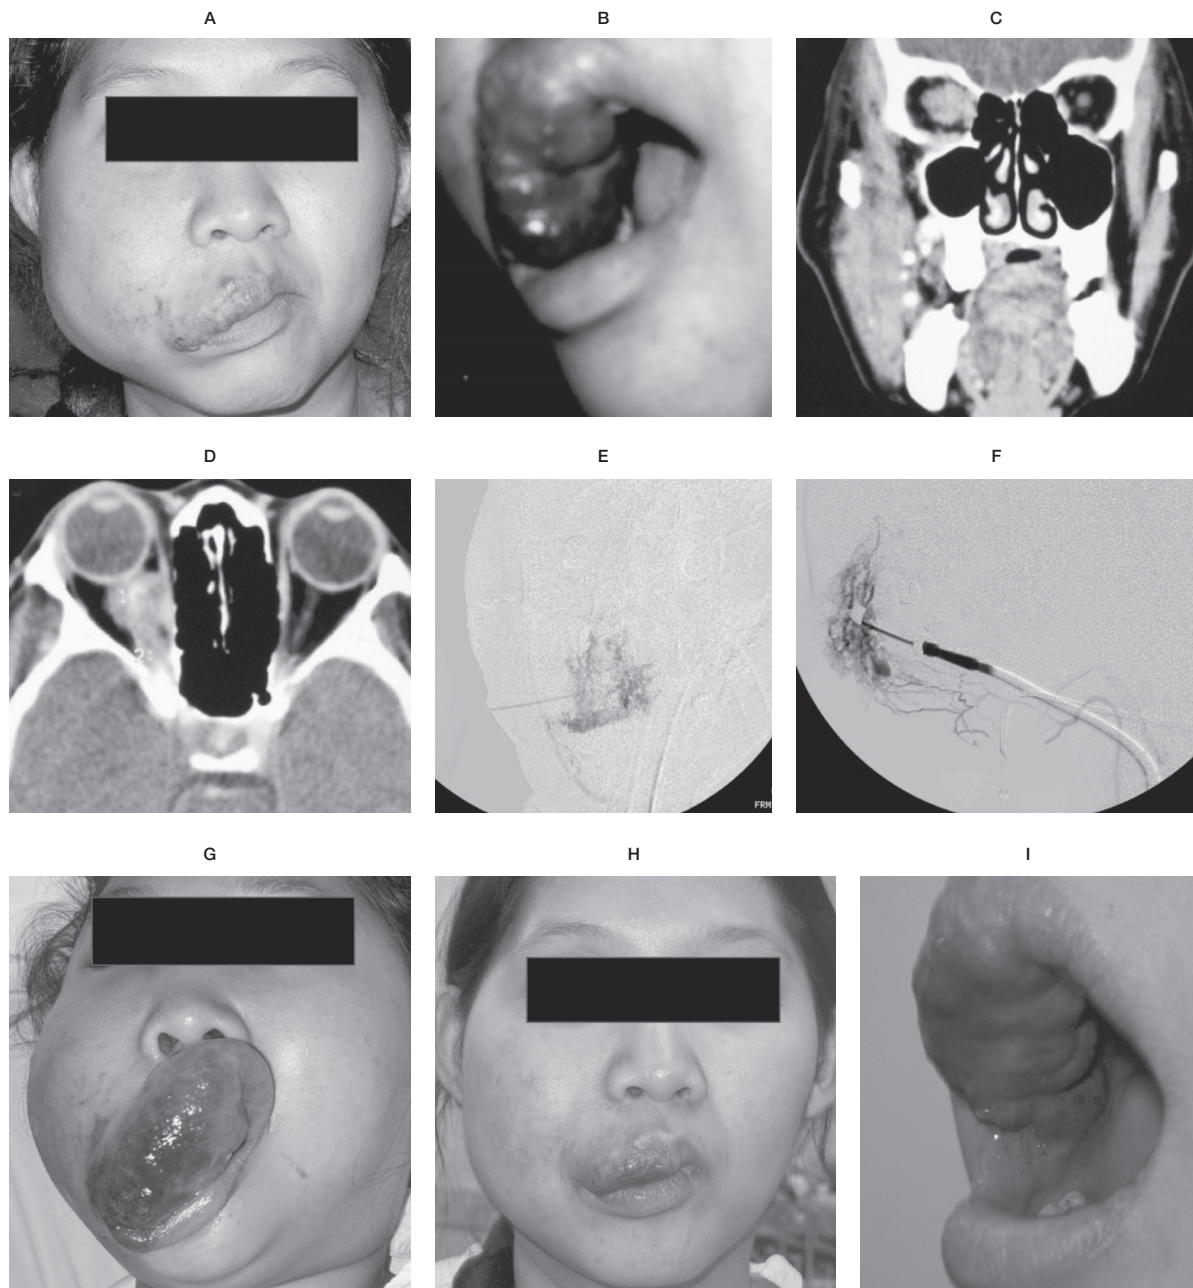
A 16-year-old female with classical presentation of venous malformation. (A,B) Venous malformation involving right cheek, buccal area and upper lip. (C) Noncontrast coronal and (D) Noncontrast axial CT scans showing extension of the lesion with involvement of right orbit. Note multiple phleboliths inside the lesion. (E) Frontal and (F) lateral projections during direct puncture with injection of mixture of ethanol and contrast media. (G) Photograph taken one day after sclerosing therapy. (H,I) Significant reduction of venous malformation after four sessions of injections (compare to A and B).
